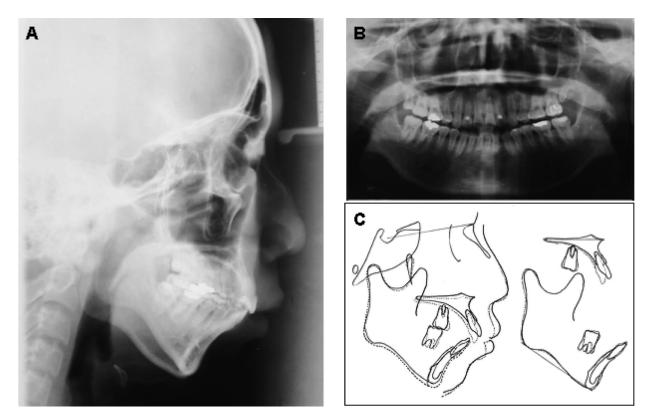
(A) Posttreatment cephalometric radiograph; (B) posttreatment panorama; and (C) superimpositions of lateral cephalograms: pretreatment (solid line) to posttreatment (dotted line).
